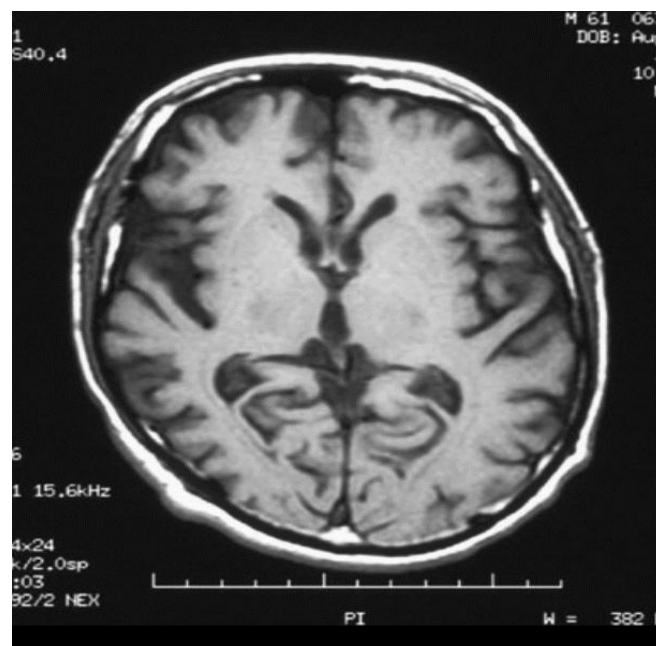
Axial, T1-weighted magnetic resonance imaging (MRI) scan shows bilateral cortical atrophy with accentuated cortical sulci; there is decreased involvement in the posterior aspect.
